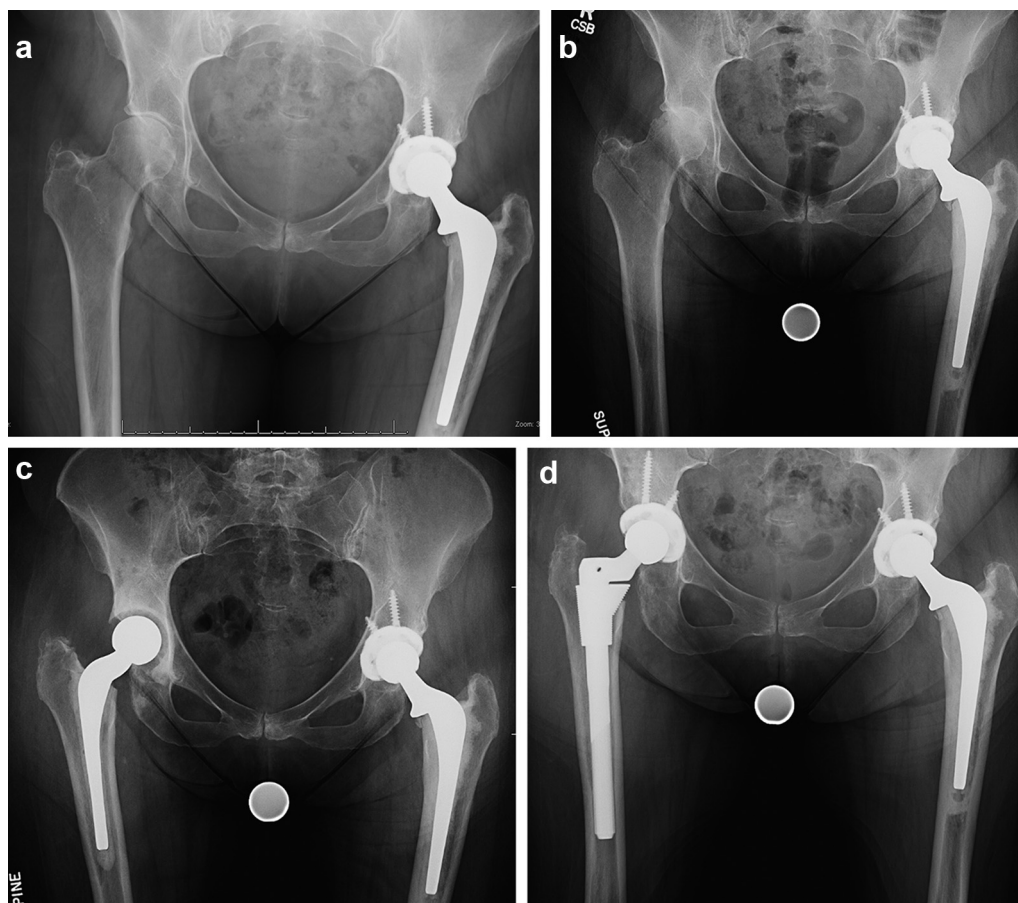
Patient 1 at follow-up for left hip (a), 3 months later with right hip pain (b), initial postoperative radiograph (c), and post-operatively 9 months after THA (d).
